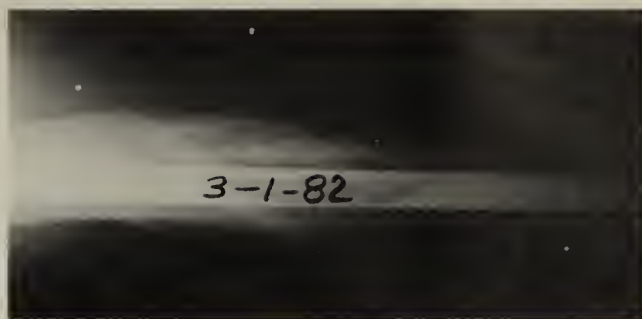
Roentgenogram of the femur demonstrating abundant callus formation and a solid union of the fracture. The marked external rotation deformity is not evident on the roentgenogram. The Kuntscher nail from the original intramedullary nailing is seen within the femoral canal.
